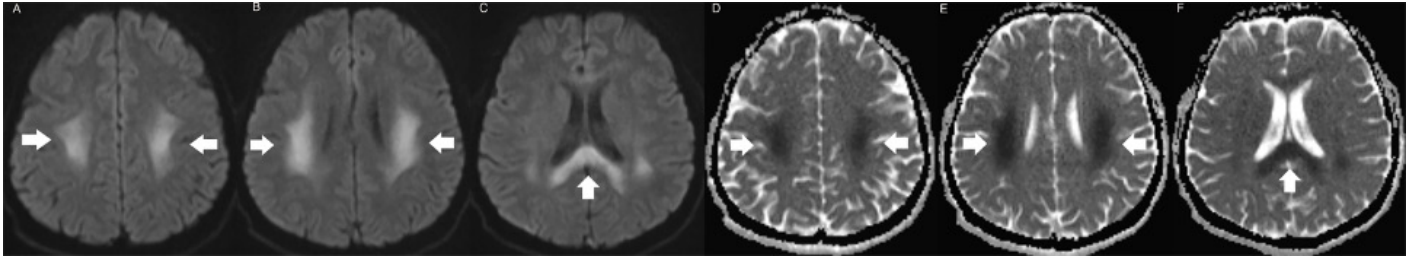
Brain magnetic resonance imaging. Axial (A, B, and C) diffusion-weighted images and (D, E, and F) apparent diffusion coefficient maps show restricted diffusion in the (A, D) centrum semiovale, (B, E) periventricular white matter, and (C, F) the splenium of the corpus callosum and the adjacent white matter
